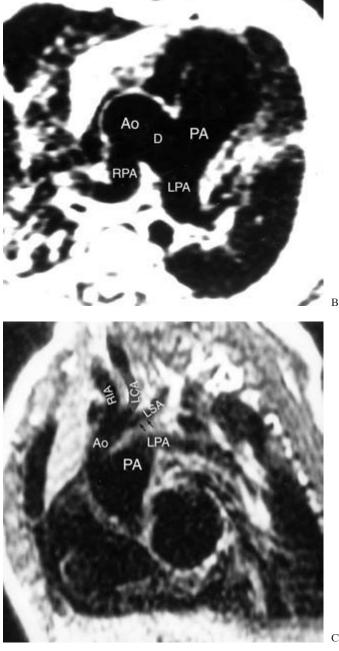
Distal type of aortopulmonary window (D) with the right pulmonary artery (RPA) arising from the ascending aorta and interruption of the aortic arch. A. MR in right anterior oblique view shows the aortopulmonary septal defect. B. MR in transverse view shows the aortopulmonary septal defect and the anomalous right pulmonary artery. C. MR in oblique coronal view shows interrupted aortic arch distal to the origin of the left subclavian artery (LSA). Ao, aorta; PA, pulmonary artery. (Reprinted from Yoo *et al.*^{25A} with permission from the American Journal of Roentgenology.)
